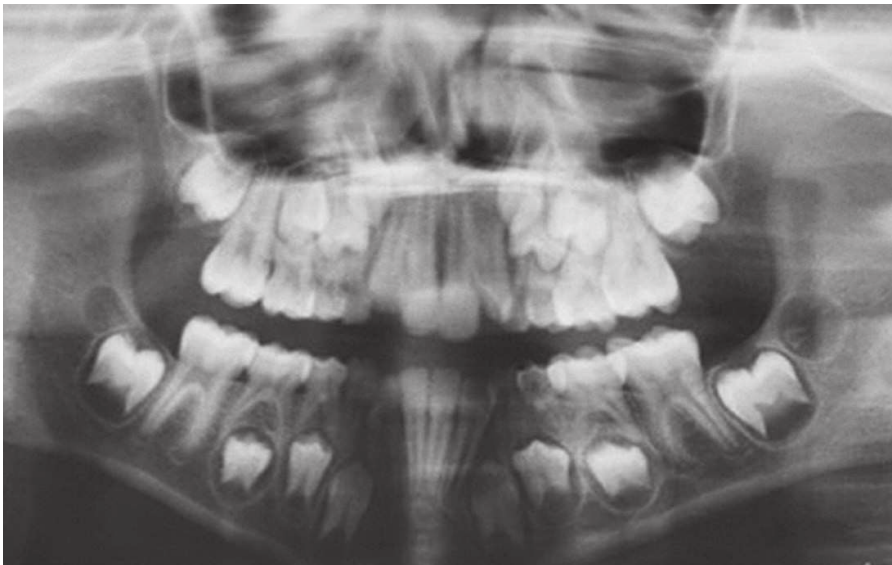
First panoramic radiograph.
